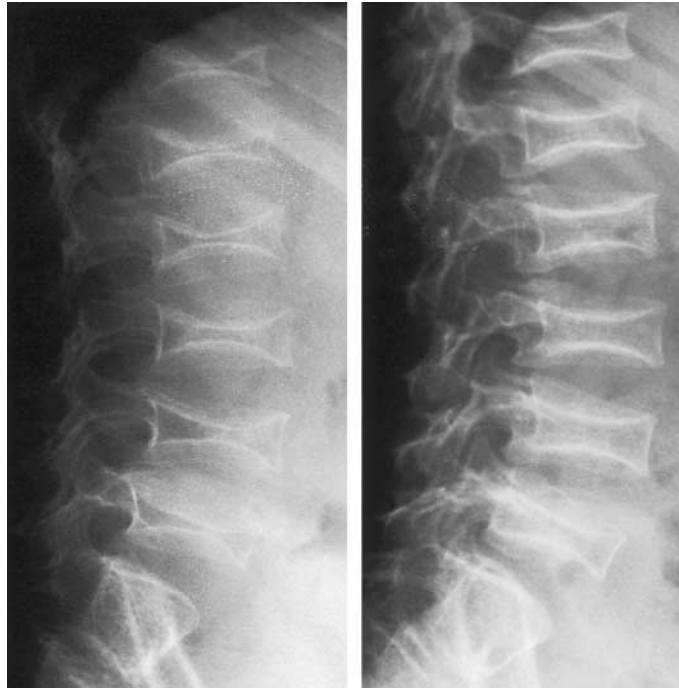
Lateral Radiographs of the Lumbar Spine of a Six-Year-Old Boy with Osteogenesis Imperfecta before (Left-Hand Panel) and after (Right-Hand Panel) 18 Months of Treatment with Pamidronate.
